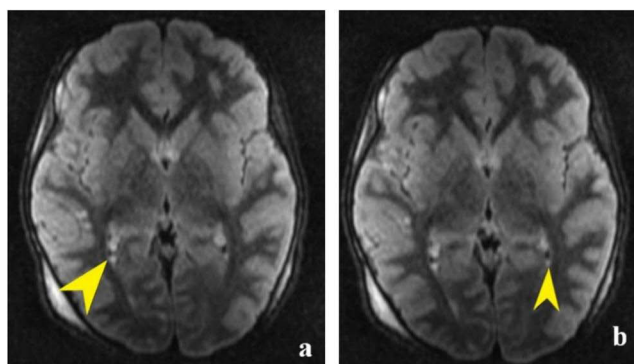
An 8-year-old girl was in a motor vehicle accident. (a and b) Small FLAIR hyperintense signal areas (yellow arrowheads) suggest intraventricular hemorrhage in the occipital horns of the lateral ventricles.
